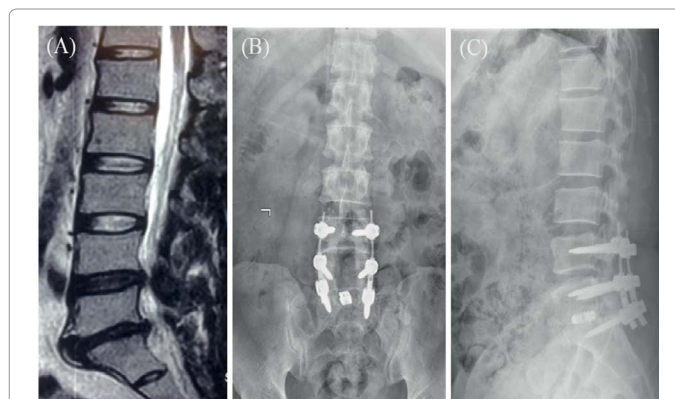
A 52-year-old male diagnosed as L4-5 and L5-S1 disc herniation in MR image (A). Radiographs of 14 months after hybrid K-rod system instrumentation in anteroposterior (B) and lateral (C) views. Dynamic fixation at L4-5 while the L5-S1 has been fixed with rigid rod with cage insertion. Good clinical outcome with adequate intervertebral space preservation at both instrumented levels without adjacent level problem.
